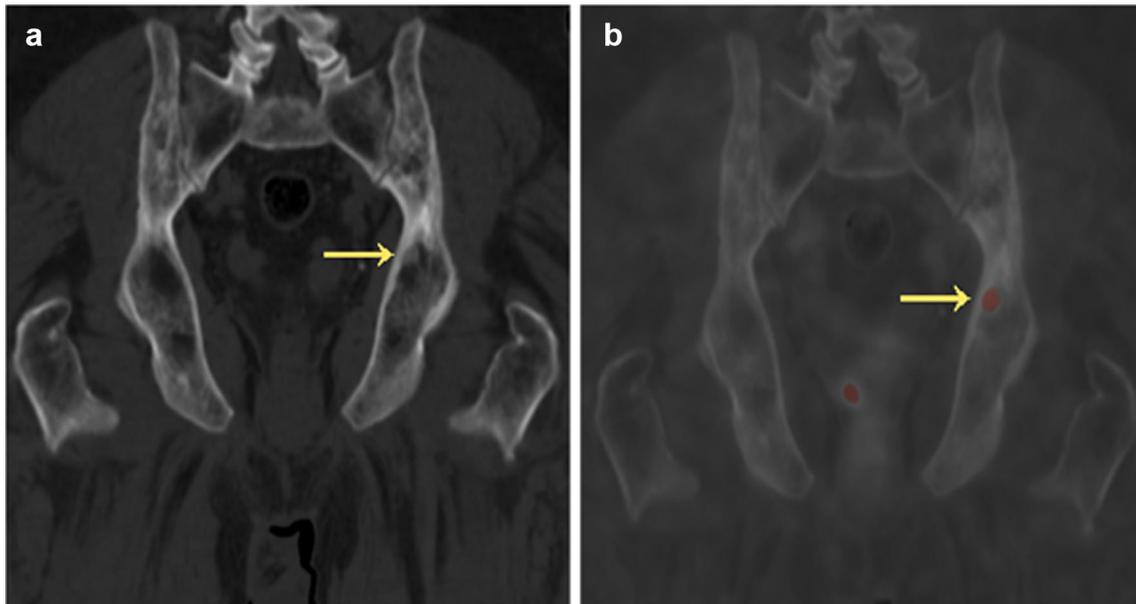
A 70-year-old man with newly diagnosed PC referred for initial staging (PSA level: 13.3 ng/mL; GS: 3+3). a Coronal CT image showing small sclerotic bony lesion at left acetabular roof (yellow arrow). b Coronal ^{68}Ga -PSMA PET/CT image reveals faint uptake at
